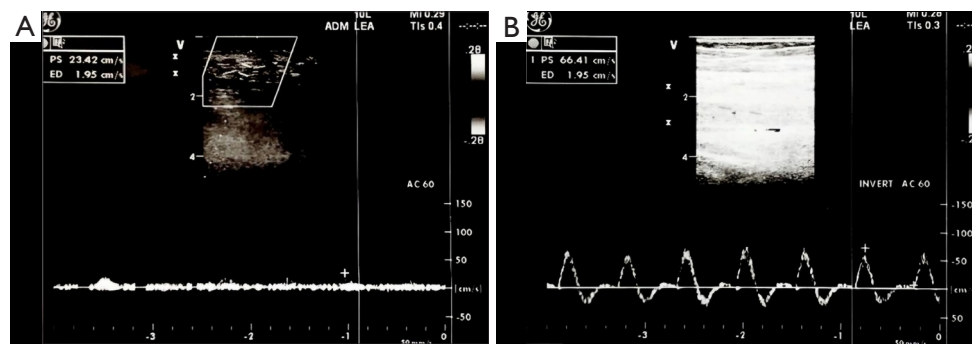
Doppler ultrasound of posterior tibial artery (A) before and (B) after Dellon Tarsal Tunnel decompression in patient with diabetic neuropathy.
